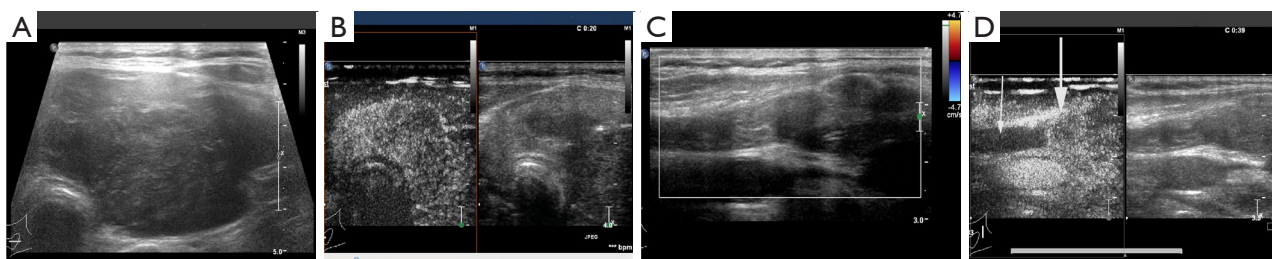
US, CEUS, and enhanced CT images of the neck in case 1. (A) A longitudinal image of US of the right thyroid gland shows an 11cm, irregular shaped, heterogeneous hypoechoic mass, replacing the entire right lobe of the thyroid, with dotted line-like blood flow signals. (B) For this mass, the contrast agent entered in a centripetal way and presented as hypo-enhancement and was heterogeneous. (C) The right internal jugular vein was filled with weak echoes, and some of the blood flow signals in the lumen were filled with defects. (D) CEUS shows that the internal jugular vein emboli presented no enhancement (thick arrow) in the central area but partial enhancement in the periphery (thin arrows). (E) Contrast-enhanced axial scan of the neck on CT revealed heterogeneous soft tissue opacities occupying the bilateral thyroid lobes and isthmus, compressing the trachea and causing tracheal stenosis (January 2019). (F) CT shows that the thyroid lymphoma went into complete remission following treatment with chemotherapy (June 2022). US, ultrasound; CEUS, contrast-enhanced ultrasonography; CT, computed tomography.
